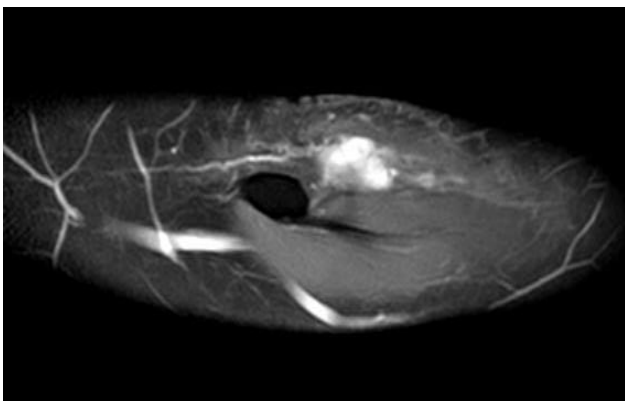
MRI picture of the lesion.
